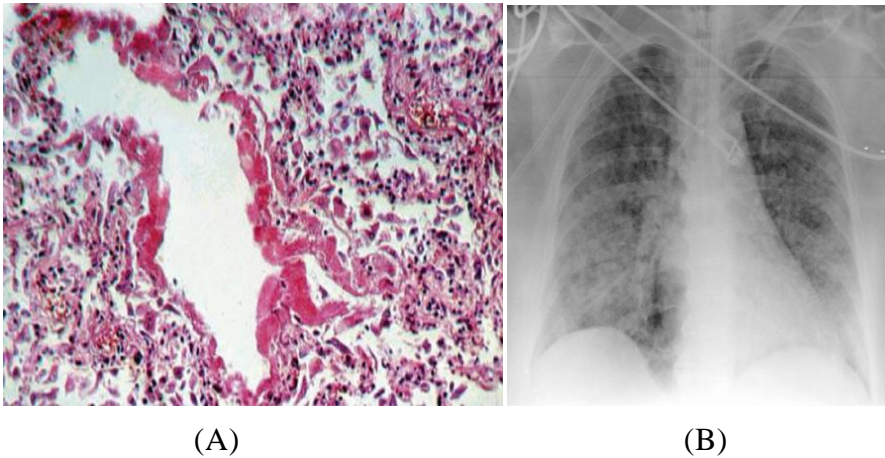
ARDS exudative phase (A) which involves a loss of alveolar epithelial cells and presents alveolar hyaline and neutrophil membranes. (B): A representative anteroposterior (AP) chest x-ray in the exudative phase of ARDS that shows diffuse interstitial and alveolar infiltrates, which can be difficult to distinguish from left ventricular failure.
